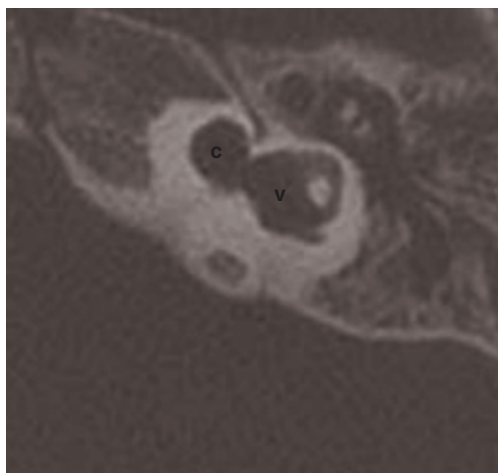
Axial CT scan. Unpartitioned completely empty cochlea (c) and dilated vestibule (v): 'incomplete partition type I'.
